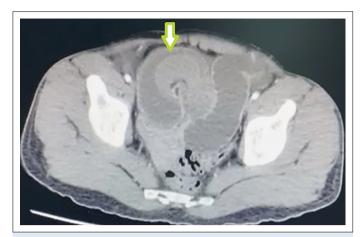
Intertwined and dilated intestinal segments in the pelvic region on CT scan (shown by an arrow).
